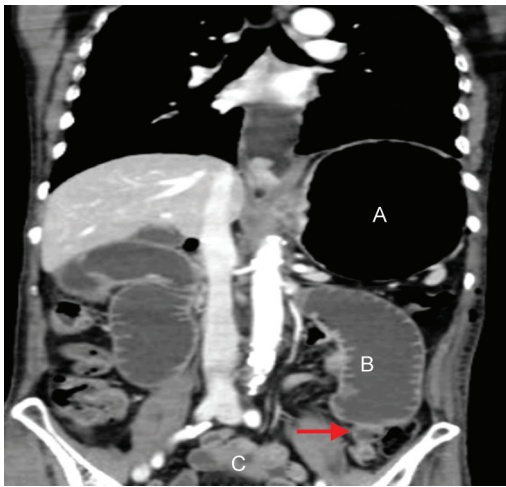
Contrast-enhanced computed tomography image, coronal section: A – distended stomach; B – duodenum; C – collapsed bowel loops distal to FJ kink site. Arrow – FJ site transition point
